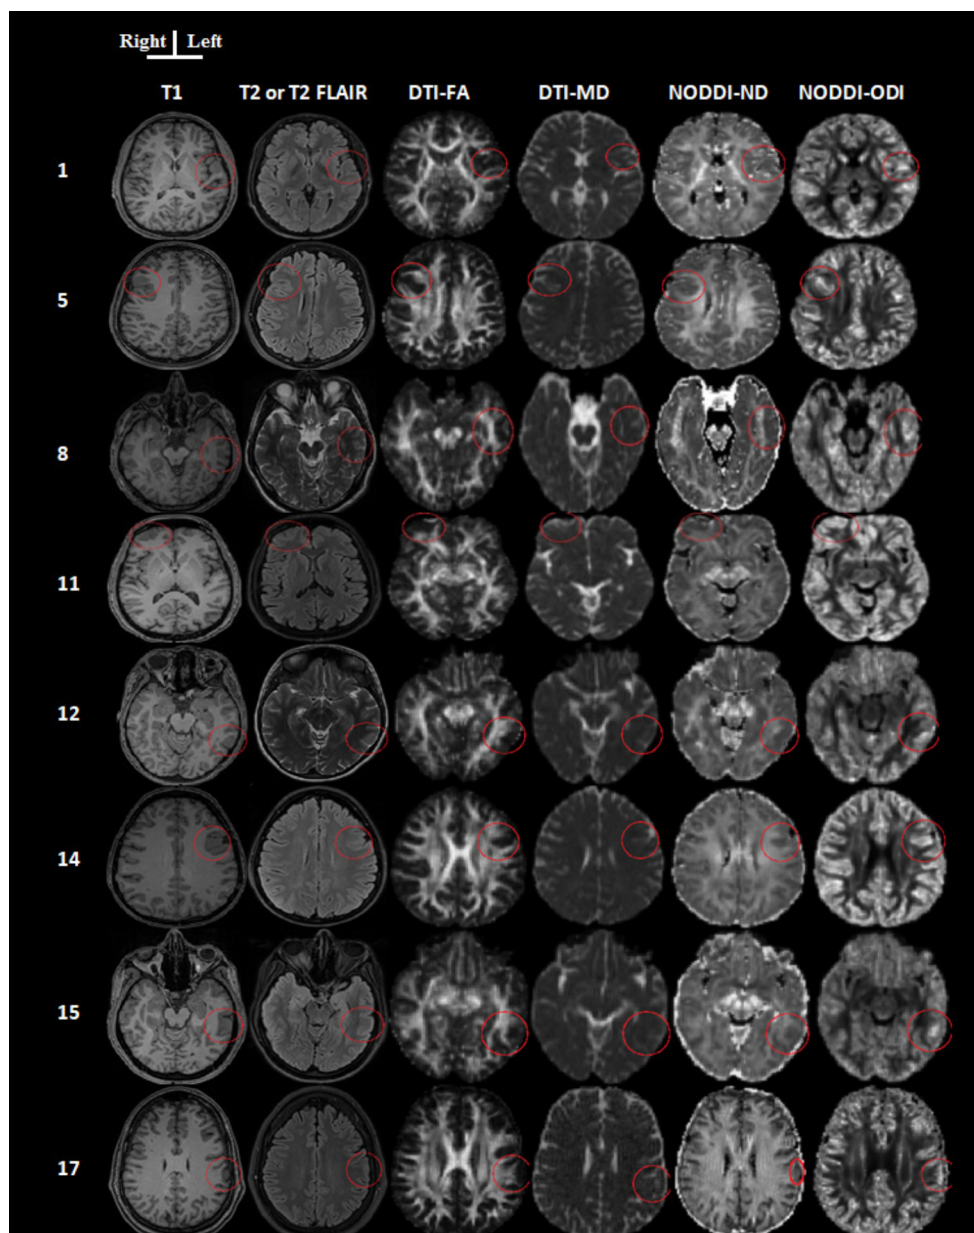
Structural, NODDI and DTI maps of eight patients with MRI-negative epilepsy.
